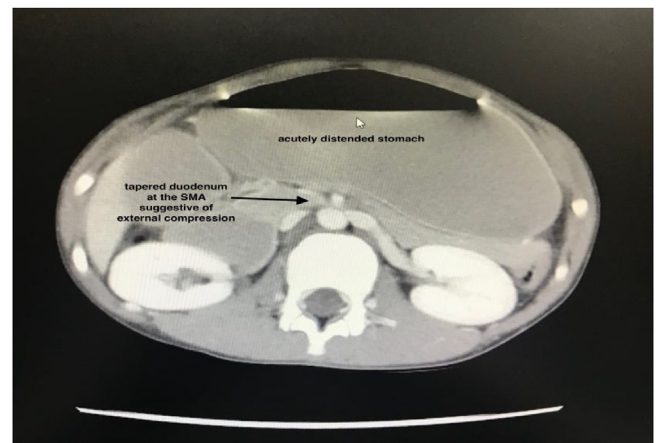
CT scan of the abdomen on the axial plane demonstrating distension of the stomach and the initial portion of the duodenum thereby causing compression of the third part of the duodenum situated between the Superior Mesenteric Artery (SMA) and the abdominal aorta.
